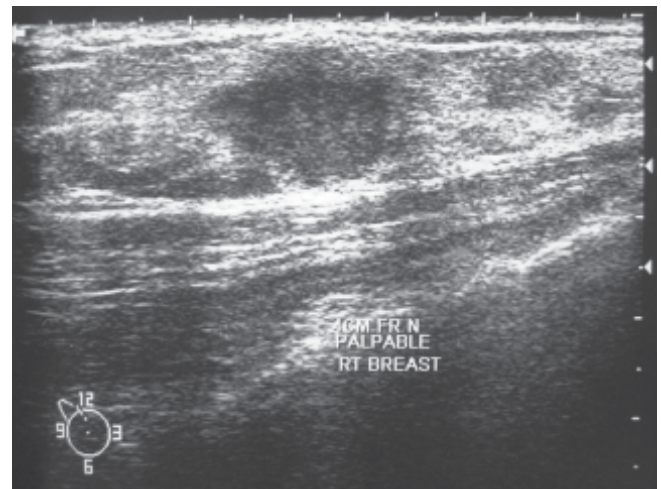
Oblique section of the same solid lump on ultrasonogram. This view confirms features of uniform echogenicity and circumscribed margins.
